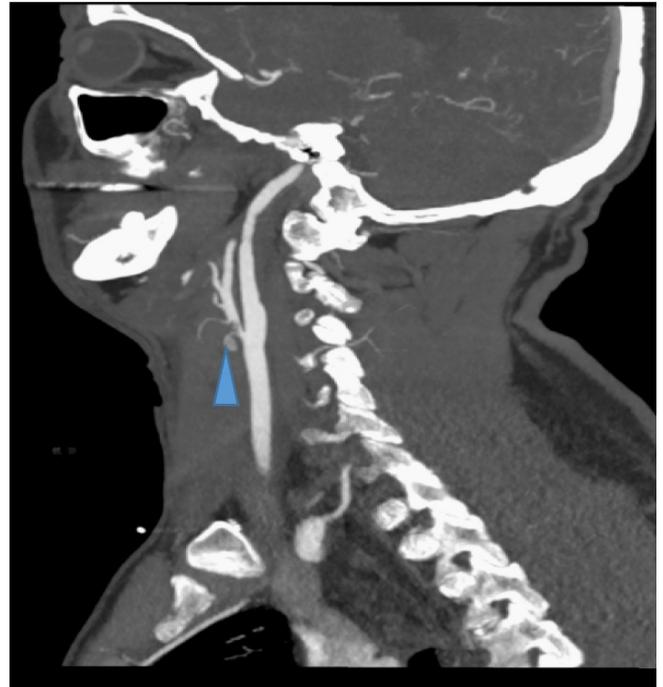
Sagittal plane maximum intensity projection images from the CTA of the neck show the small pseudoaneurysm arising from the proximal external carotid artery (arrowhead).
